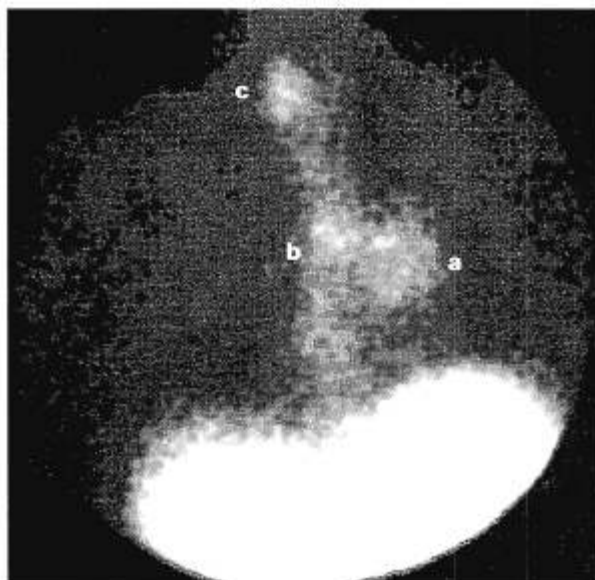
A large primary tumour is seen in the left lung field in the region of the hilum (a). Pathological uptake is also seen throughout the mediastinum, particularly adjacent to the hilum (b) and to the right of the trachea (c). Single-photon emission computed tomography (SPECT) imaging further localized the disease, demonstrating not only mediastinal adenopathy but also pathological accumulation of the radiolabel in the sternum and thoracic spine (not shown).
